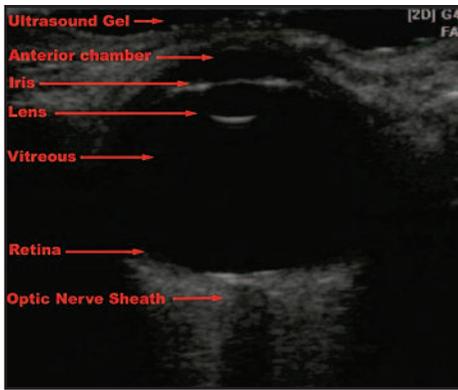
Ocular ultrasound anatomy
